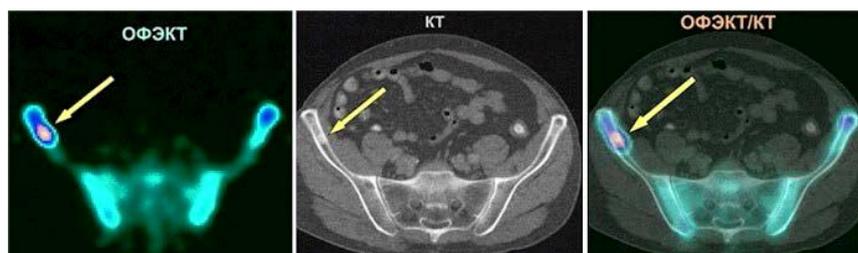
Comparative characteristics of SPECT and SPECT/CT for the detection of metastasis in breast cancer
